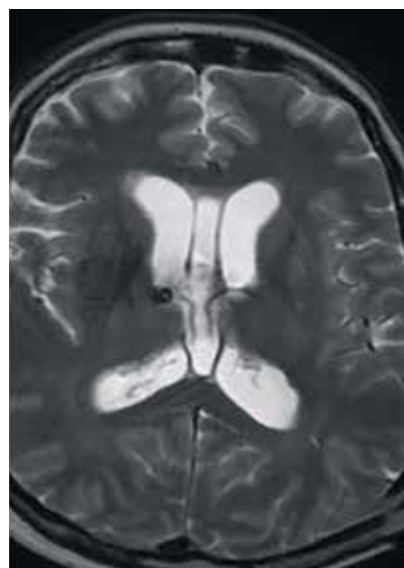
Postoperative axial T2-weighted magnetic resonance imaging showing the initial reduction of hydrocephalus and the ventricular catheter placed in right ventricle
